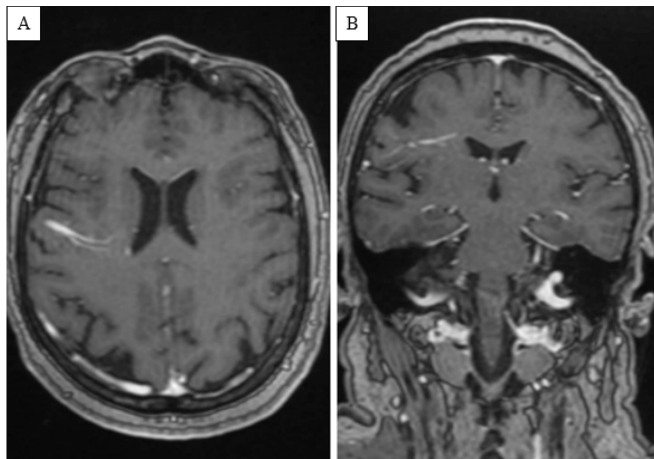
Axial (A) and coronal (B) T1 post-contrast MRI sequences venous phase showing straight posterior front dilated venous tract head branching, extended to the deep white matter level, which spills into a cortical vein draining into the superior sagittal sinus.
